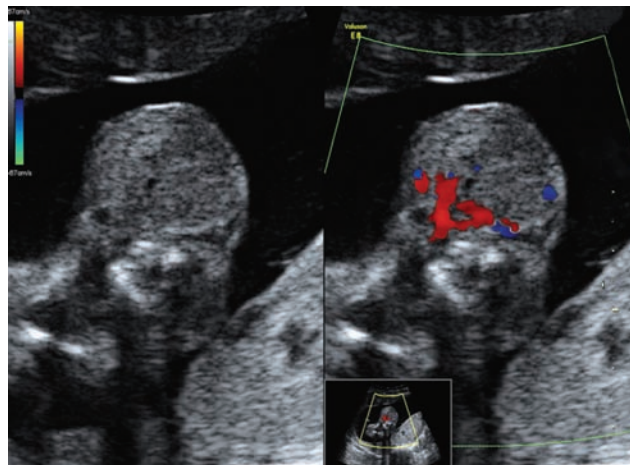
Color Doppler of the cervical tumor that demonstrates poor vascularization
